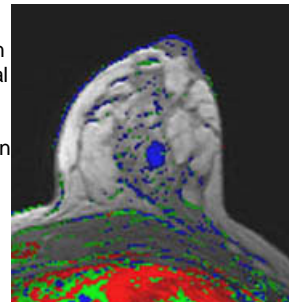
35 year old woman with fibroadenoma in the left breast. 3TP MR image shows bright blue pixels in the whole lesion.
